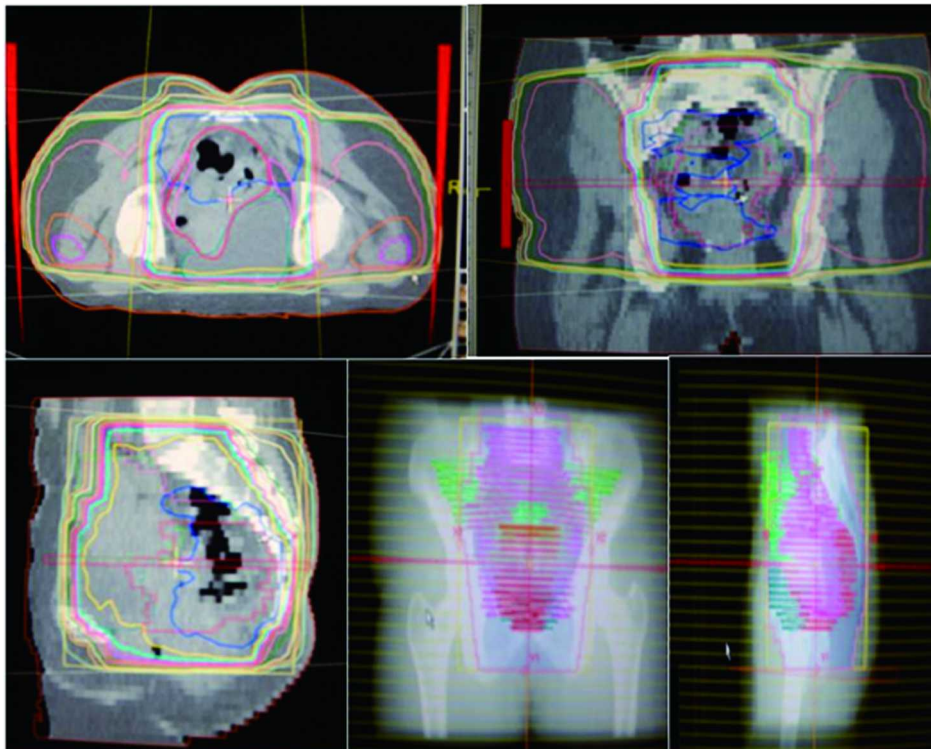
Treatment techniques used for radiotherapy (a) prone position with three field technique , (b) & (c) coronal and sagittal views of multi planar reconstructed (MPR) showing isodose distribution , (d) Posterior and lateral portals on digitally reconstructed radiographs (DRR) showing gross tumor volume , lymph nodes and boundaries.
